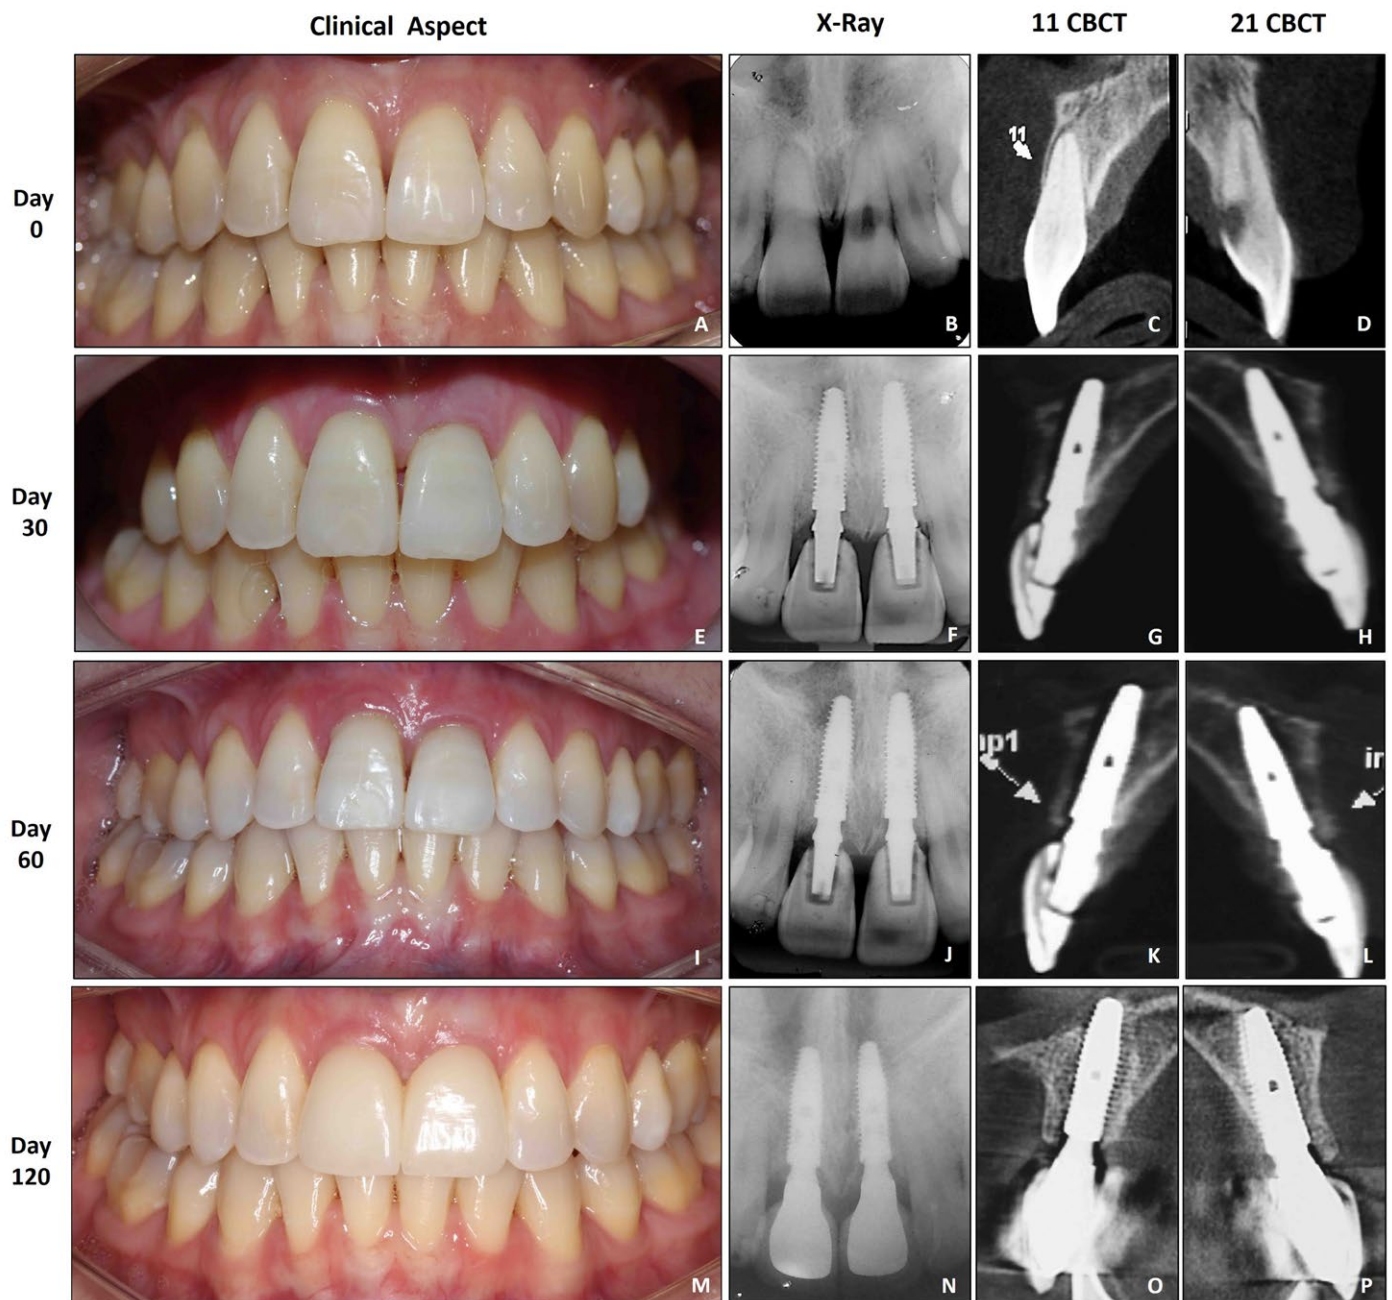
A, B, C & D) The Initial clinical aspect where the rehabilitative aim by dental implants will occur in teeth #11 and #21 and respectively X-ray and CBCT. Note the quality of the gum tissue and health, as the slender phenotype making it very difficult treatment. E, F, G, H) 30 days postoperatively after dental implants installation, the x-ray showing CBCT maintaining the vestibular bone. I, J, K, L) 60 postoperative days of dental implants placement. Note, both rx and in CBCT the maintenance of bone tissue. M, N, O, P) 90 days postoperatively. The respective radiographic and tomographic examinations have in maintaining the quality of the bone tissue and the line obtained by this technique.
